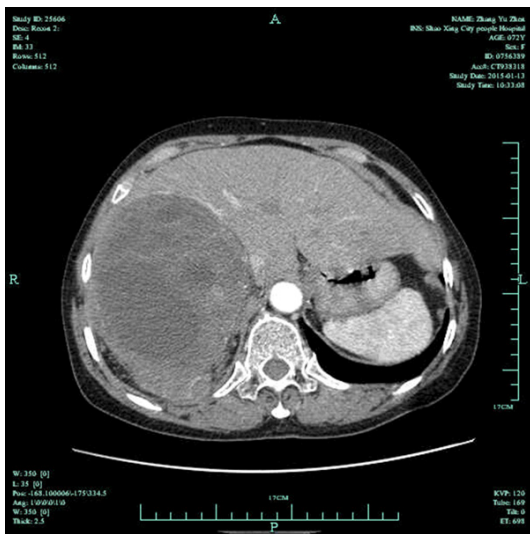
Mass in the CT scan.
